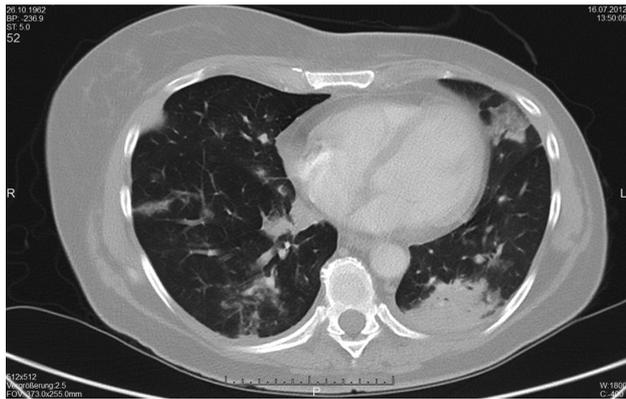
Thoracic CT-scan, acquired in pulmonary window, previous to initiation of treosulfan in July 2012.
